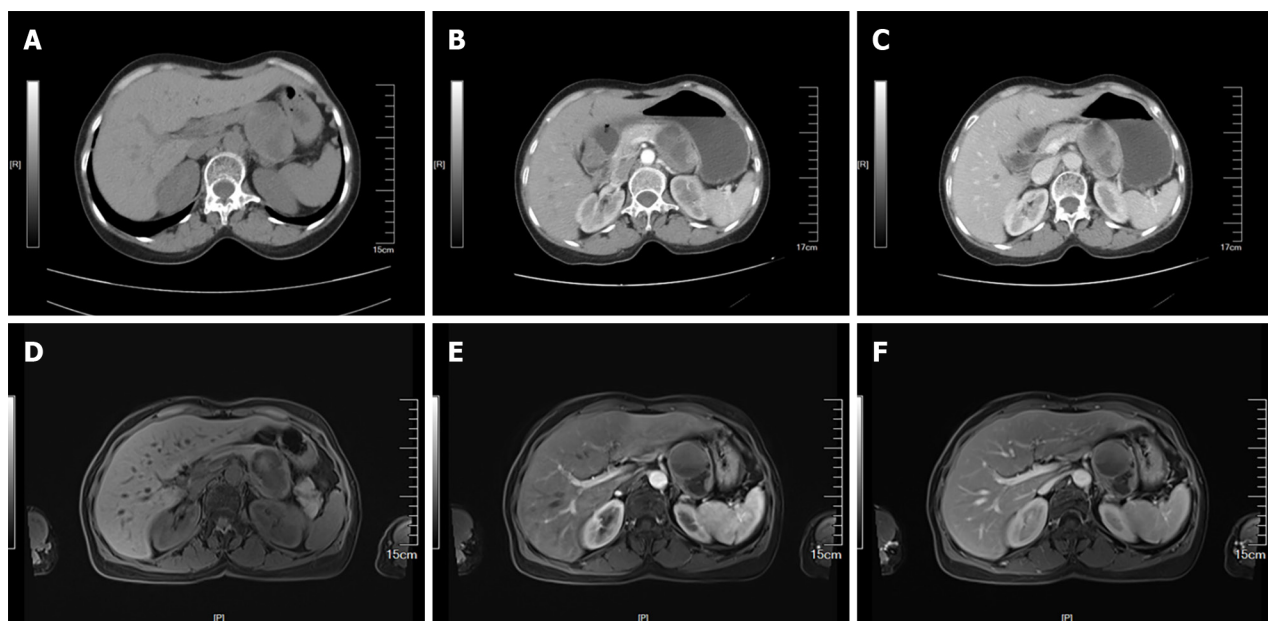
Abdominal computed tomography and magnetic resonance imaging show a 6.5 cm × 4.5 cm cystic solid mass in the left upper abdomen with heterogeneous density and mild enhancement in the arterial phase. A: Computed tomography (CT) plain scan period; B: CT arterial phase; C: CT venous phase; D: Magnetic resonance imaging (MRI) plain scan period; E: MRI arterial phase; F: MRI venous phase.
